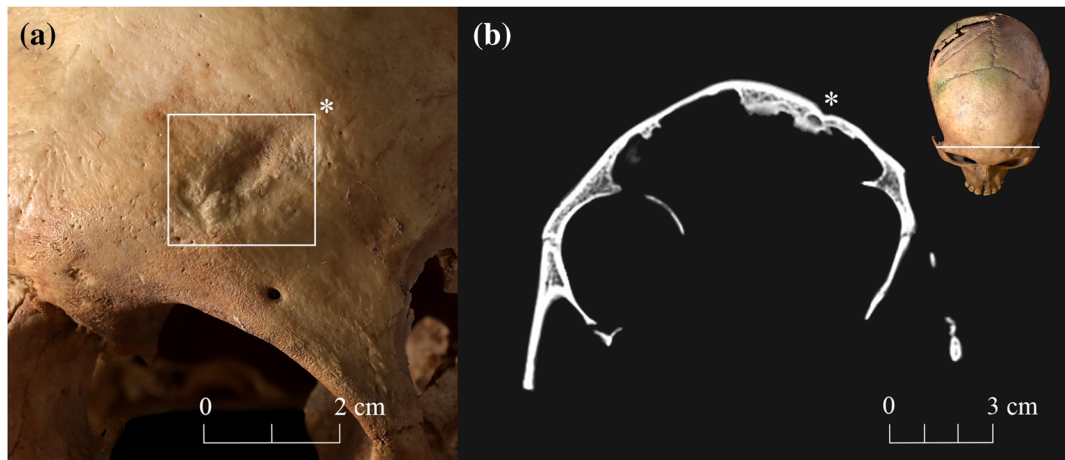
Lesion #1. (a) Antero-lateral view of the cranium with the depressed lesion in square. (b) Computed tomography in the coronal plane (upper right corner) showing the approximately 1.5 mm depth of the lesion [Colour figure can be viewed at wileyonlinelibrary.com]
